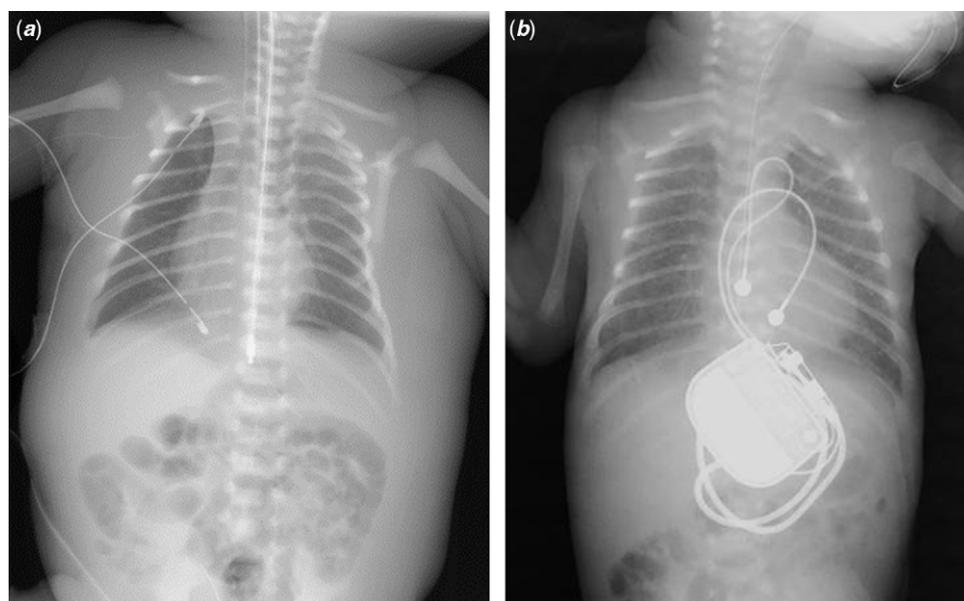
X-rays. (a) The esophageal lead is positioned (day 5). (b) A permanent pacemaker was implanted in the abdomen of a very-low-birth-weight infant. The subcutaneous edema improved (day 31).
